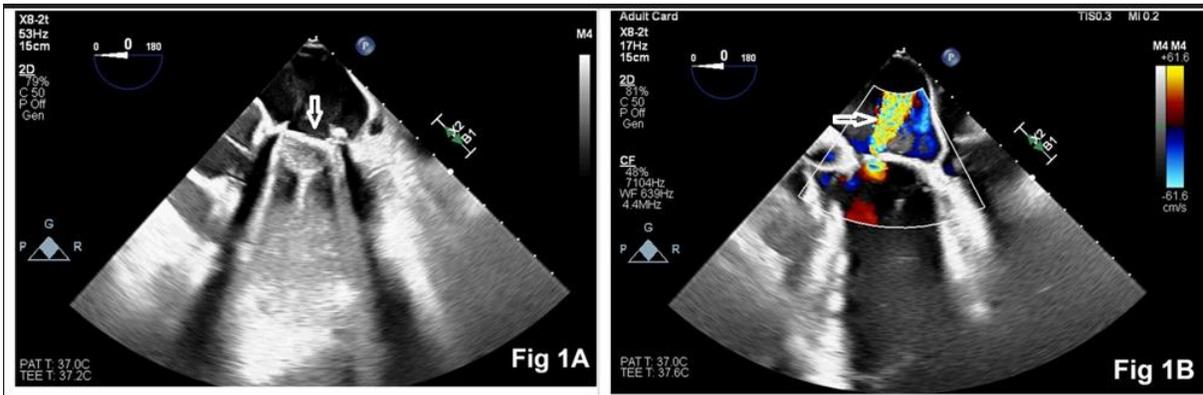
Two-dimensional echocardiography showing prosthetic valve at mitral position (Figure 1A) with paravalvular leak at the medial commissure (Figure 1B).
